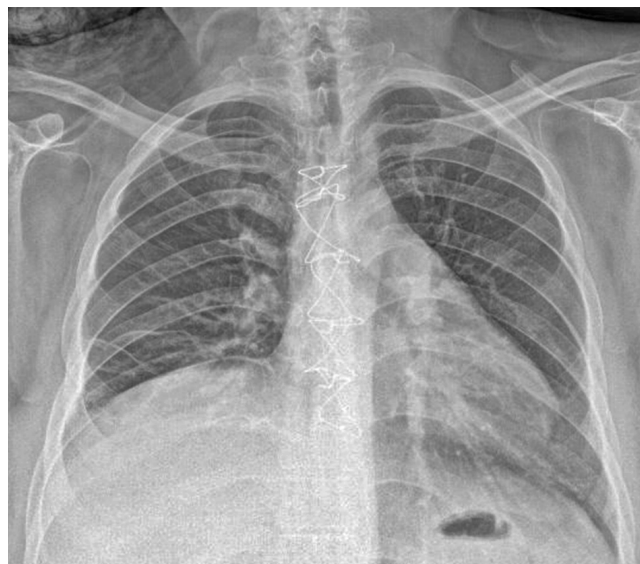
Control X-ray upon discharge of the patient without evidence of pleural effusion, without data of mediastinal widening, with sternal fixation.
